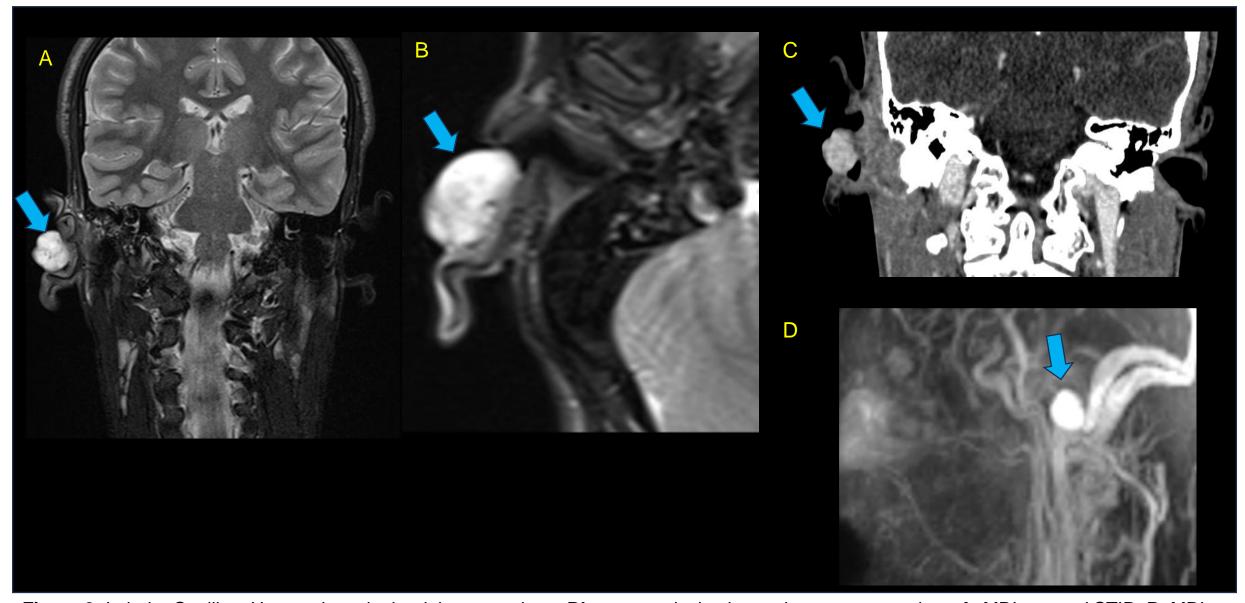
Lobular Capillary Hemangioma in the right external ear. Blue arrow: lesion located on cavum conchae. A: MRI, coronal STIR. B: MRI, axial STIR. C: Contrast-Enhanced Computed Tomography, coronal. D: MRI, dynamic angiographic study shows vascular component with arterial pattern filling, with branches from the posterior auricular artery, and the presence of large drainage veins.
